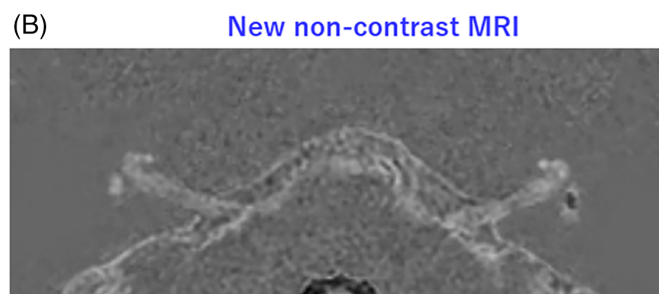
New non-contrast MRI of Patients 5 and 6. Patient 5 was a 47-year-old woman with Stage 3 right-sided Ménière's disease. Patient 6 was a 51-year-old woman with Stage 3 left-sided Ménière's disease. (A) Image of the inner ear at the cerebellopontine angle of Patient 5. (B) Image of Patient 6. (C) Magnified images of the inner ears of Patient 5, and (D) magnified images of the inner ears of Patient 6. Lesions in Patients 5 and 6 with decreased signal intensity are apparent in the new non-contrast MRI; they are consistent with the images considered to represent endolymphatic hydrops in the vestibule and cochlea.
